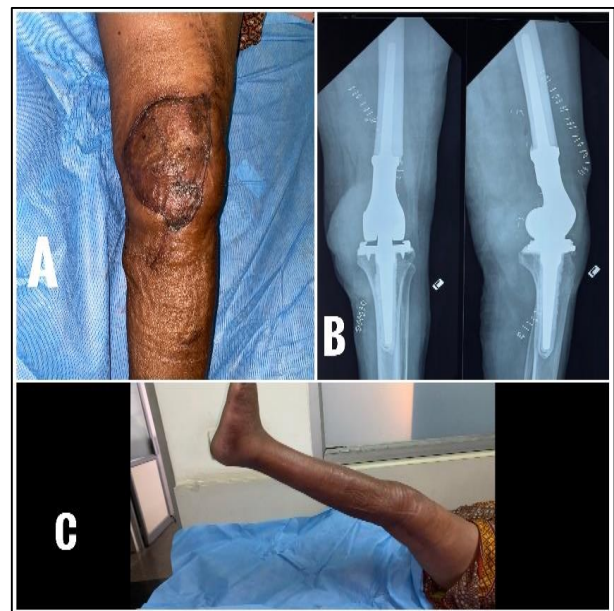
(A-C): Post-operative radiological and clinical image. Post-operative clinical image showing the healed graft wound. Post-operative radiograph showing in-situ prosthesis. Six months post-operative clinical imaging showing 10 degrees of extensor lag on straight leg rising.
